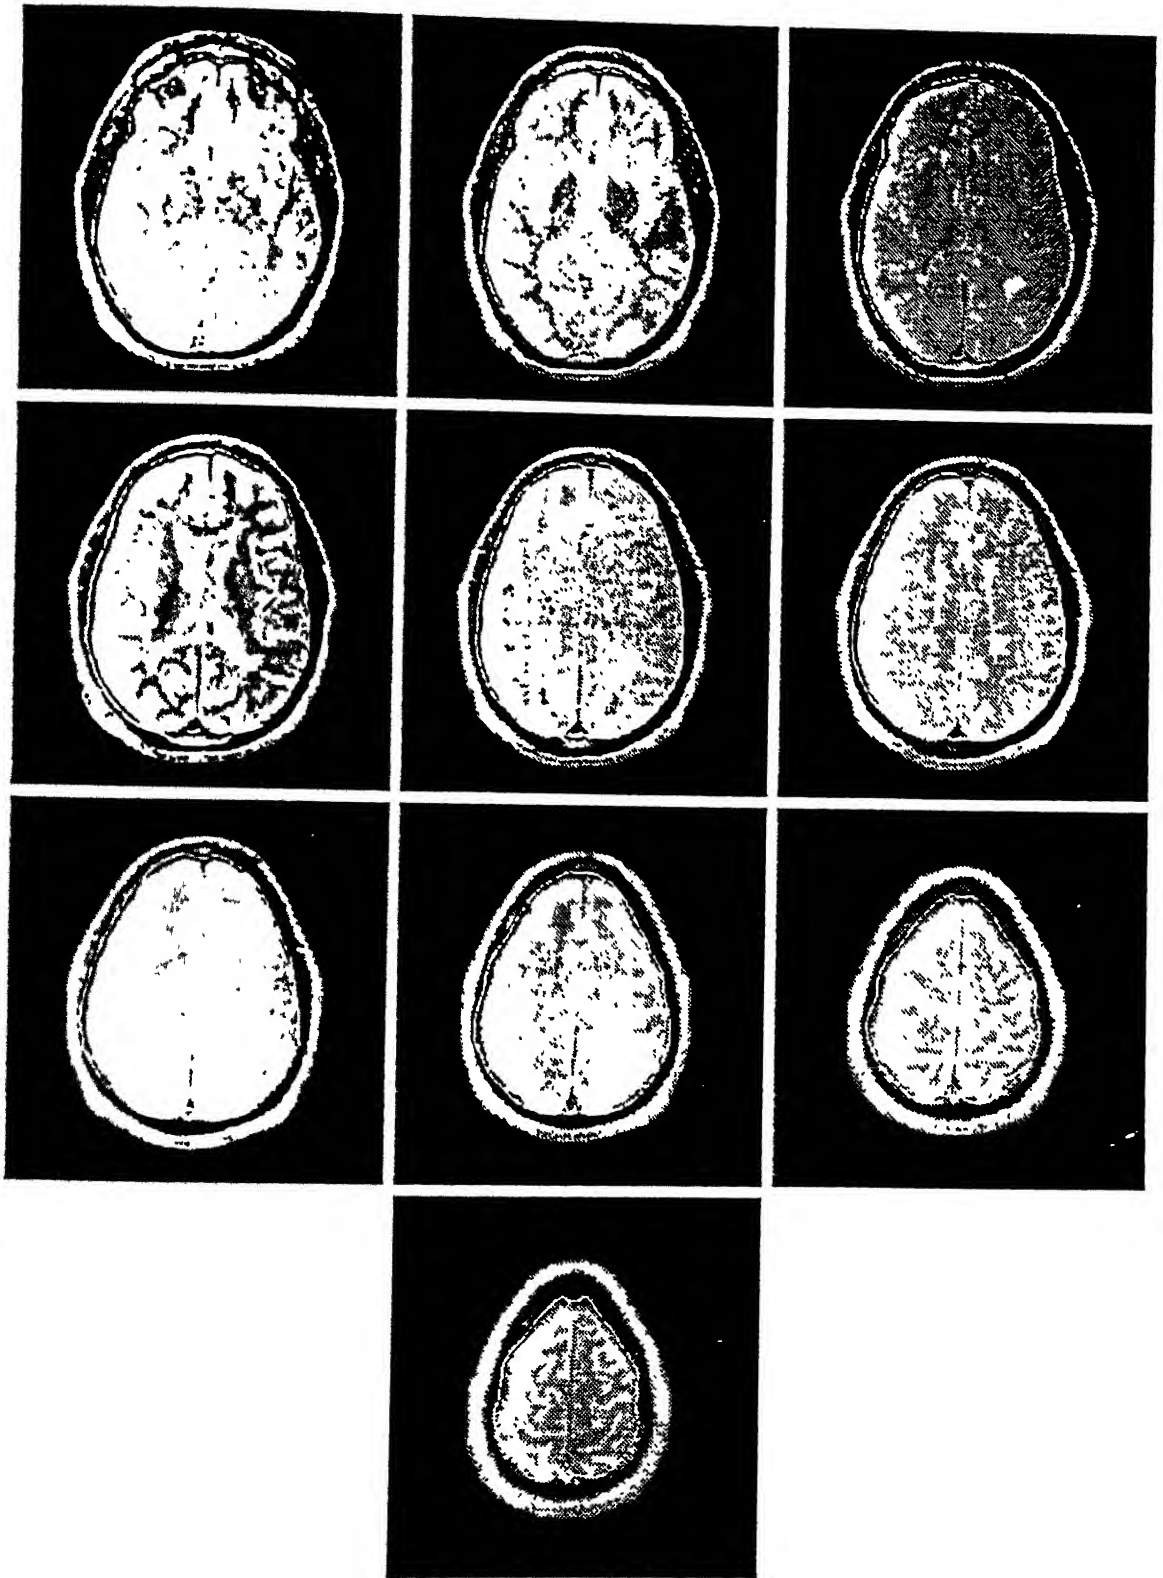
The Brain Mask for MRI Data Set 3 overlaid on the PD-weighted scan: Slices 11-20.
